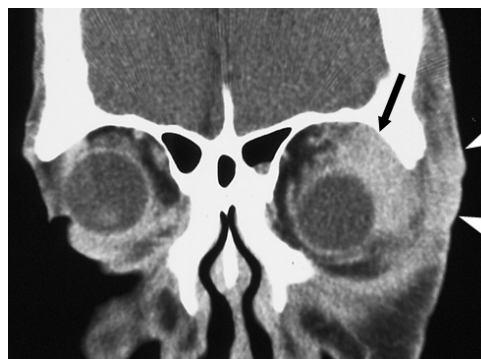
An inflammatory pseudotumor in a 54-year-old woman. A contrast-enhanced CT scan shows an ill-defined enhancing mass in the superior lateral aspect of left eye globe (arrow). Subcutaneous infiltrations (arrowheads) are accompanied in the lateral outside of the left orbit.
